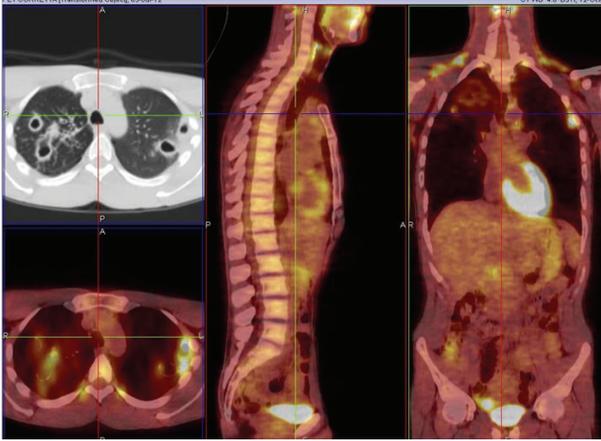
M. kansasii* infection, cavitory lesions in the right upper lobe and in the apical segment of the right lower lobe and left upper lobe, SUV max 5.36. Related to patient 3 (PET/CT. Courtesy “V. Monaldi” Hospital).
